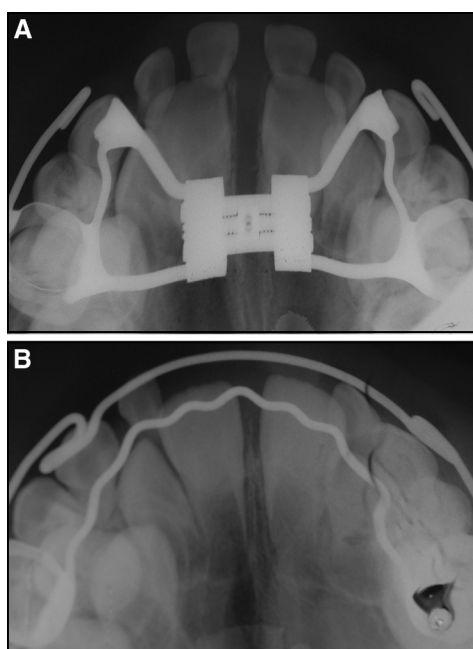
Occlusal radiographs in patient 1: A, after active RME treatment; B, 1 year from the end of active expansion therapy.
